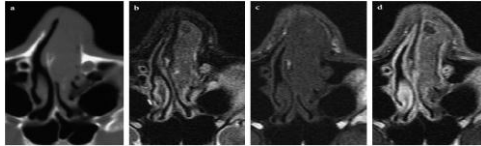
Melanoma of the left nasal cavity. Axial CT (a), TSE T2 (b), unenhanced (c), and enhanced (d) T1. The tumor presents as a polypoid mass, filling the nasal cavity, without specific signal features.¹²
